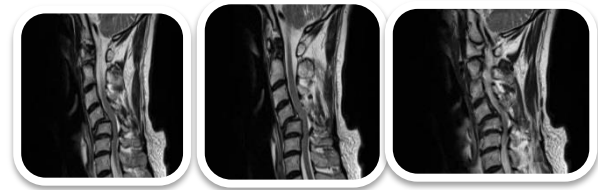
Cervical magnetic resonance imaging (MRI) showing grade 2 anterolisthesis of C4 on C5 with severe central canal stenosis and cervical cord compressive myelopathic change in C4 till C6
